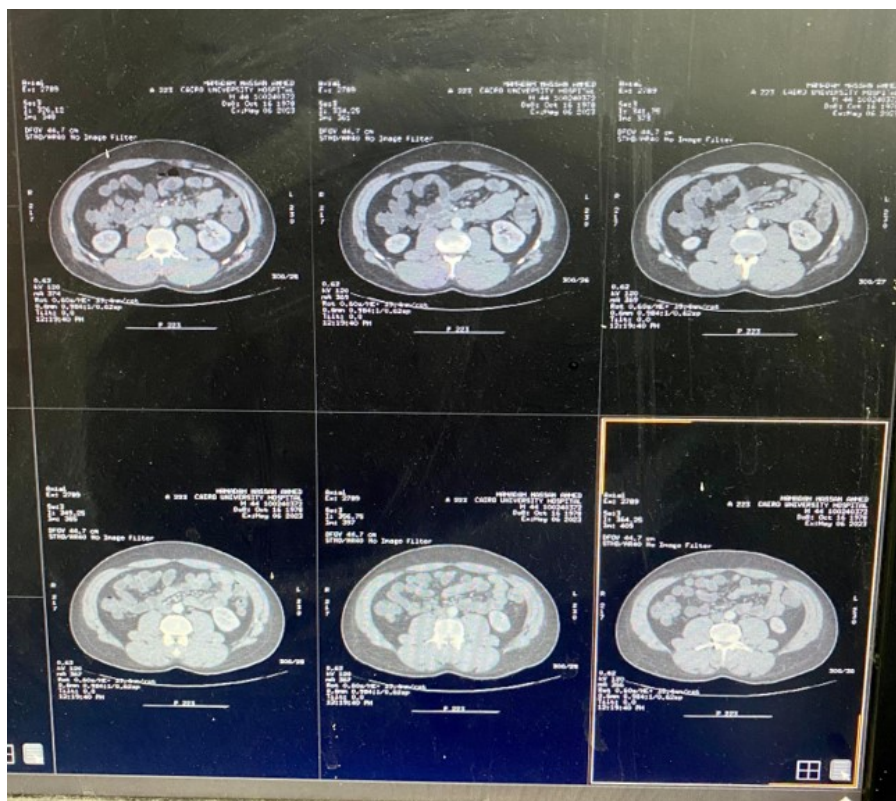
Triphasic CT scan of the abdomen was unremarkable
